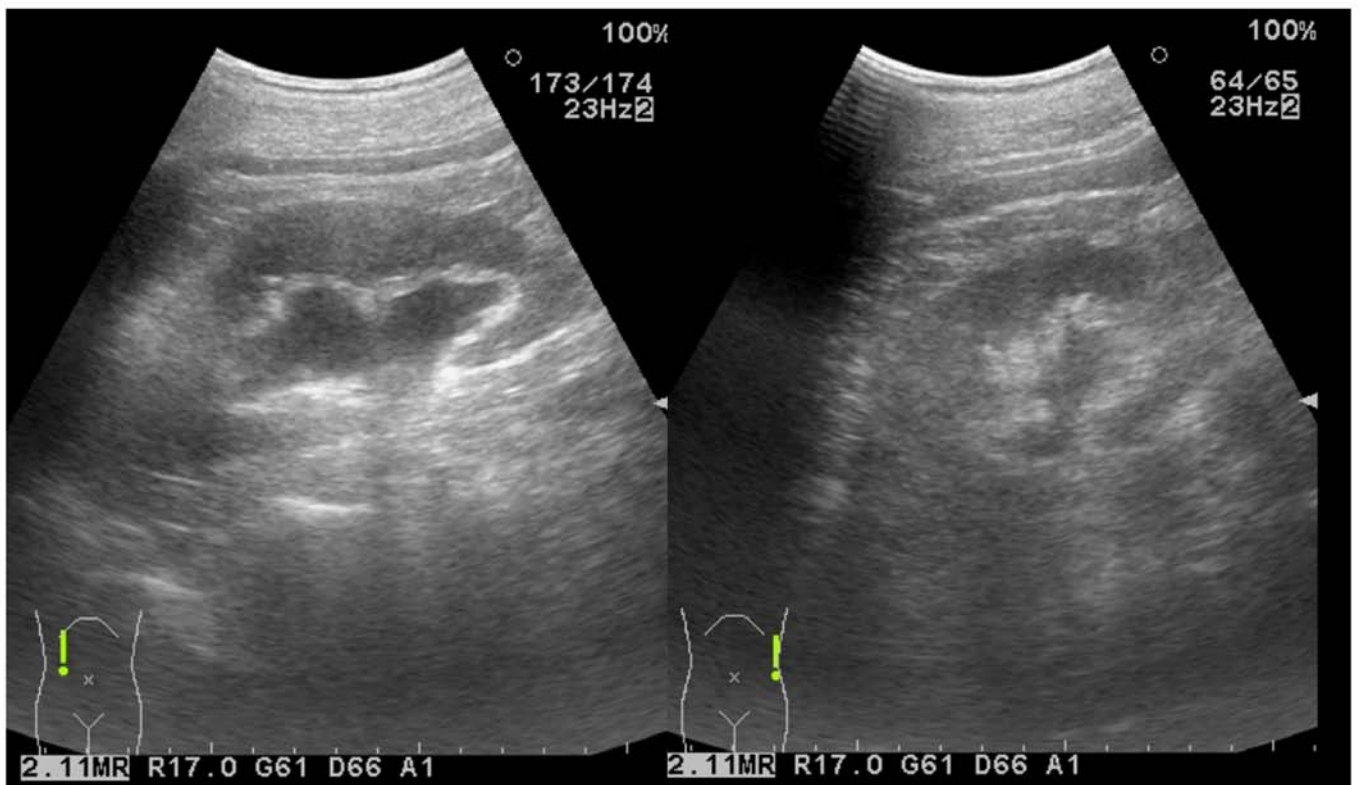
Ultrasonography reveals bilateral grade 2-3 hydronephrosis.
